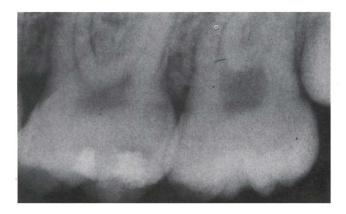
At 6 months: Figure 2a. Radiographically, both lesions are definitely visible above the two separate radiopaque CompS/C restorations.
